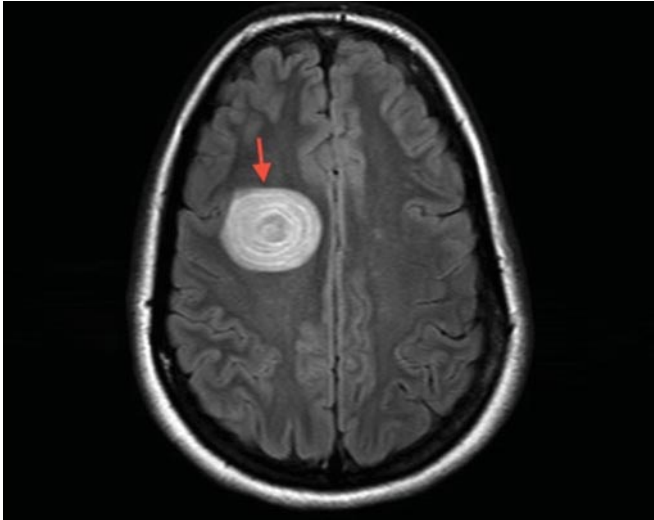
Axial T2-weighted fluid-suppressed MRI at the level of the anterior cingulate gyrus showing a large (>2cm) hyperintense ovoid lesion with ring enhancement and mass effect.
